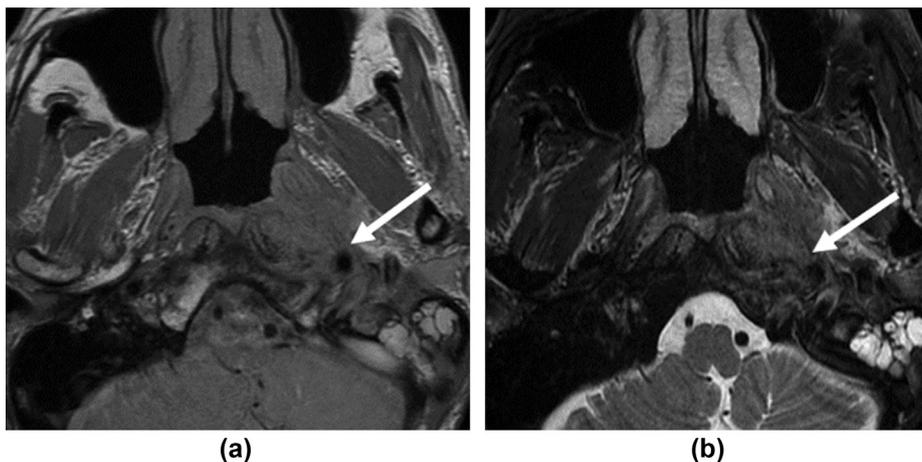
Carotid space involvement of the NPC on Axial T1 and T2-weighted image (arrow in A and B) showing loss fat separation plane with the left internal carotid artery.
